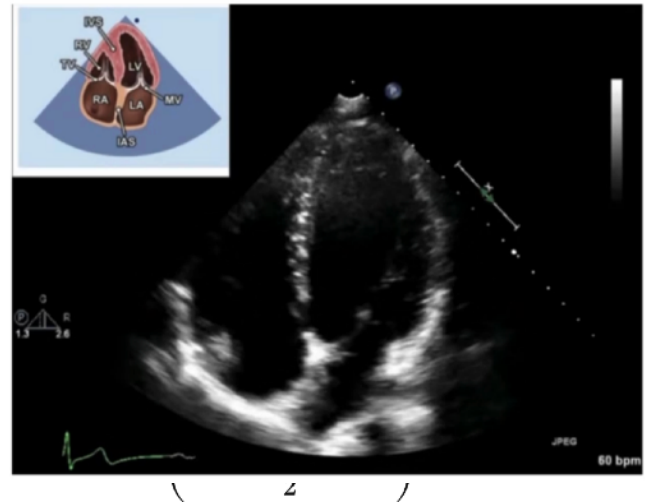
Apical four-chamber echocardiographic view demonstrating the four cardiac chambers.
